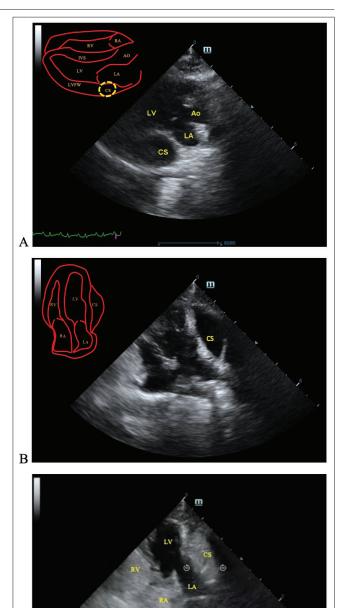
2-D echocardiographic images showed a dilated coronary sinus (CS) just beneath of the left atrium (LA) at the right parasternal long axis view (A) and through the LA free wall at left apical 4-chamber views (B). CS was detected as a circular (A) or elliptic dark shape (B). 2-D echocardiographic images before (B) and just after agitated saline injection (C) at the left apical 4-chamber views. Microbubbles were seen firstly as hyperechoic content into the CS, and then right atrium (RA) and right ventricle (RV), confirming the presence of persistent left cranial vena cava (PLCVC). LV: left ventricle, Ao: aorta
